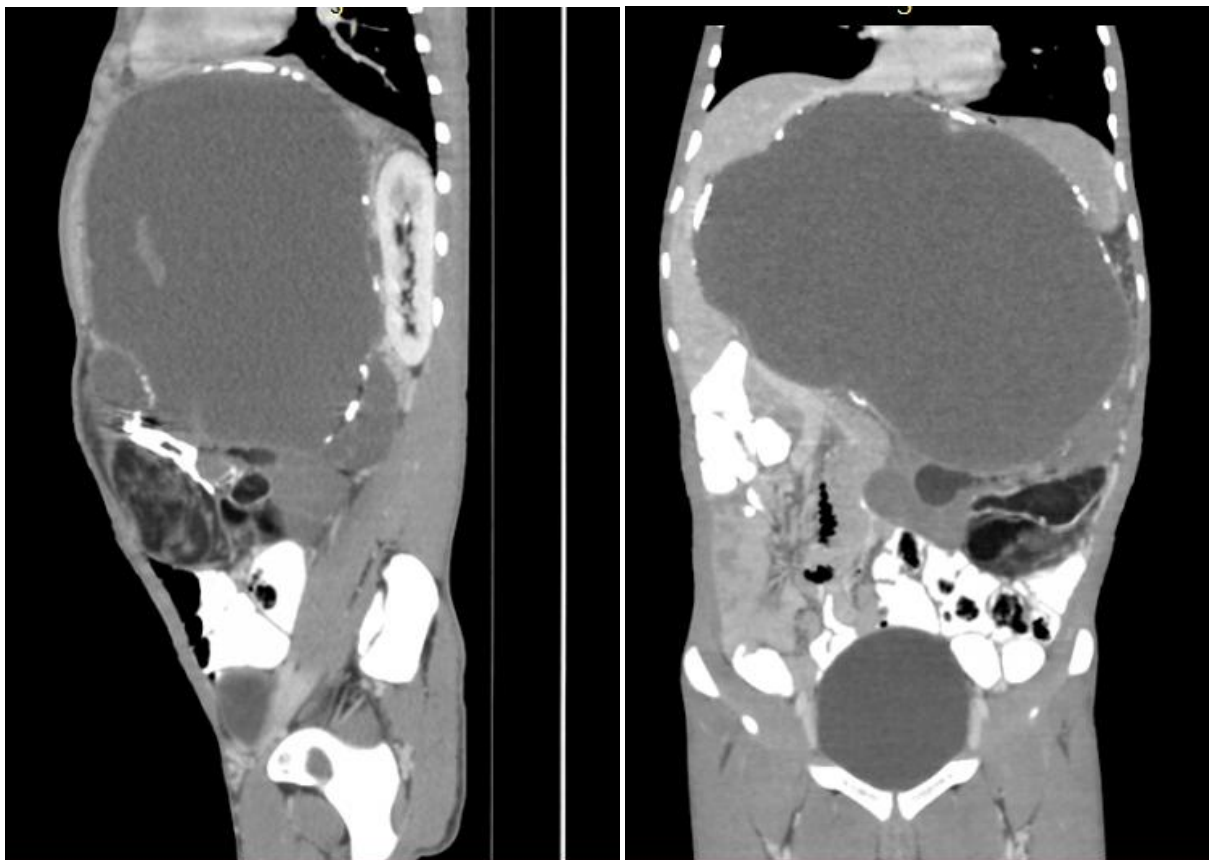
Coronal and sagittal venous phase CT abdomen shows right side displacement of major vessels (IVC & Aorta) and their branches. However vessels show normal post contrast enhancement.
